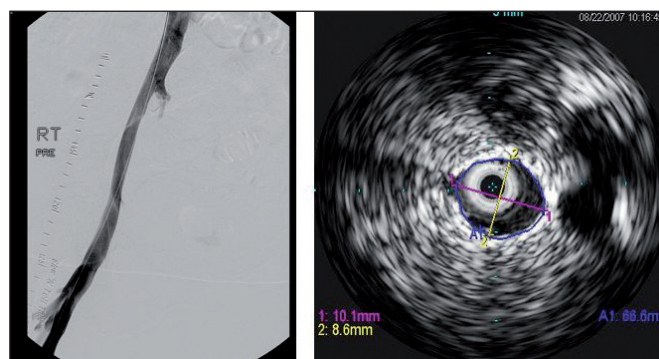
Ascending venography and intravascular ultrasound (same patient)
